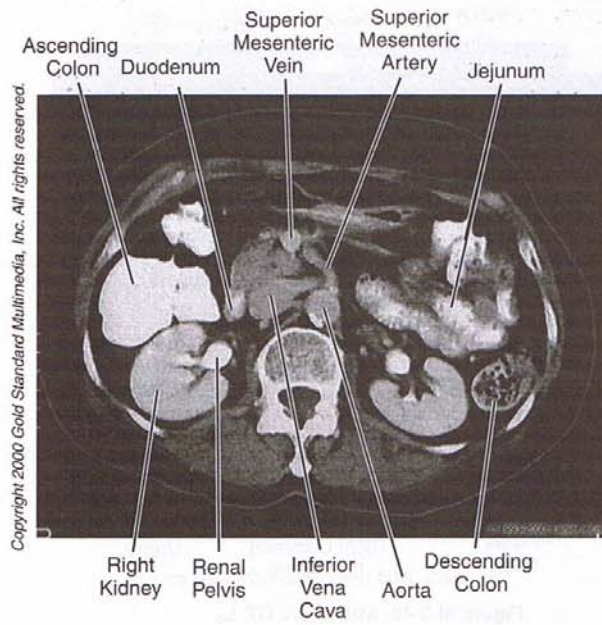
Abdomen: CT, L₂
